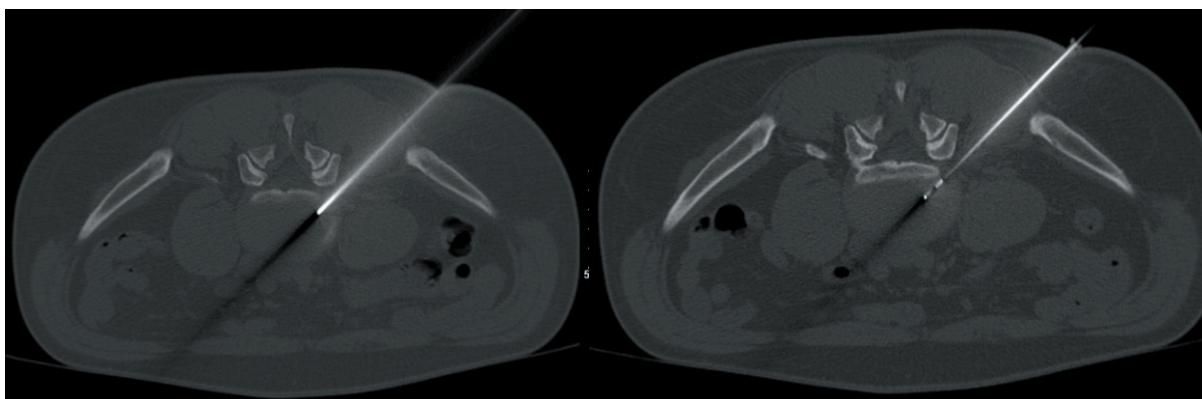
Percutaneous plasma disc decompression under CT guidance.
